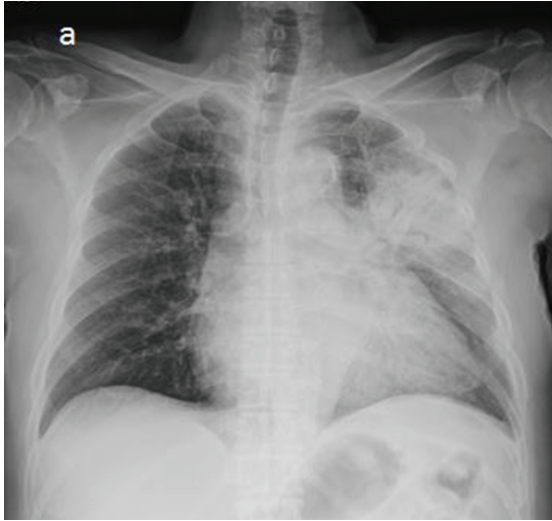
Initial chest X-ray upon arrival.
